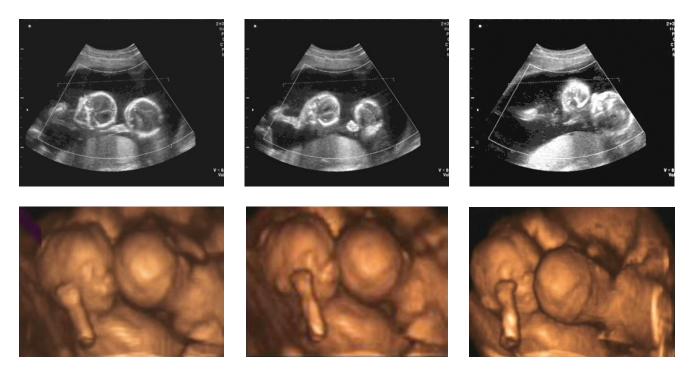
Comparison between two techniques to evaluate fetal behavior. Using real-time 2D sonography (upper series), hand to head contact together with head to head intertwin contact can be recognized. Due to sectional imaging it is impossible to categorize hand to head contact. In the lower sequence of images, the advantages of spatial visualization are clear. Hand to head movement can be differentiated from hand to ear contact following movement of the right hand forward. Head to head intertwin contact can be determined in detail. The forehead of one twin contacts with the cheek of its co-twin. Furthermore, the facial expression of one twin is discernible
